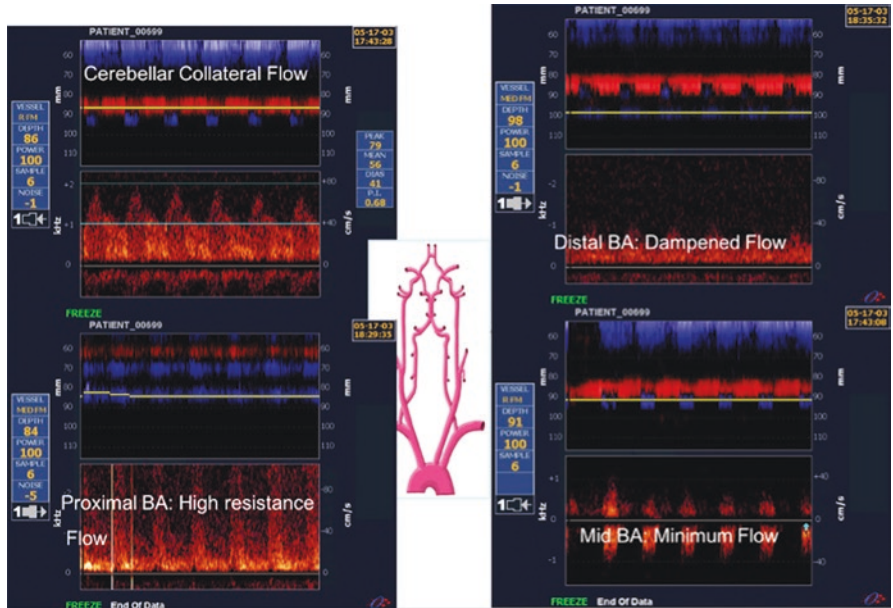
Power M Mode/Transcranial Doppler showed mid basilar artery (BA) occlusion: cerebellar collateral arteries are seen at depth 84 mm (most likely from anterior inferior cerebellar artery branch)
